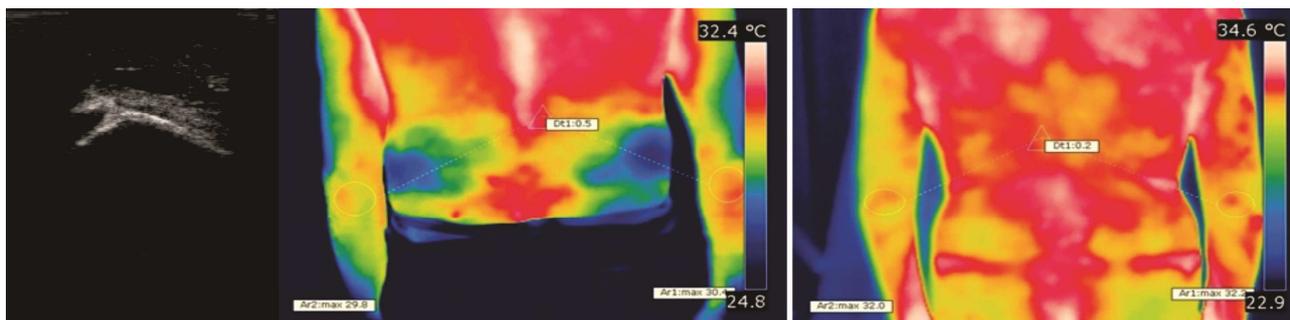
Olecranon bursitis ultrasound and thermography before and after treatment ( $\Delta T$  decrease from 0.5 to 0.2°C)
